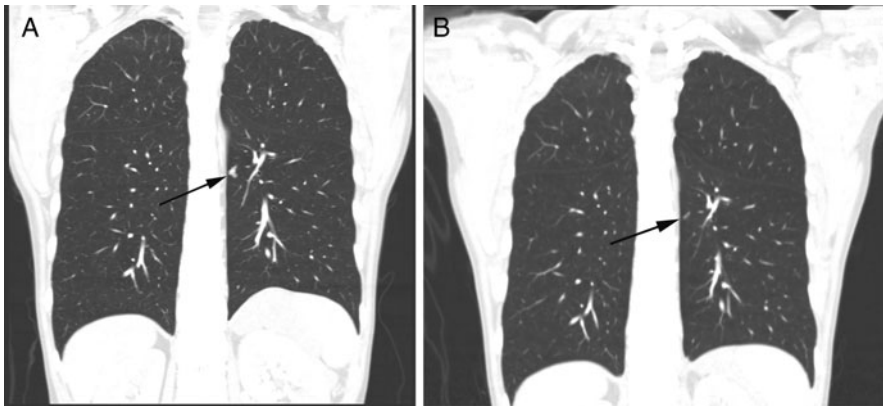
Chest CT scan (a) shows a small left lung nodule (arrow) that subsequently responded to four cycles of systemic chemotherapy (b, tumor remnant arrow)
